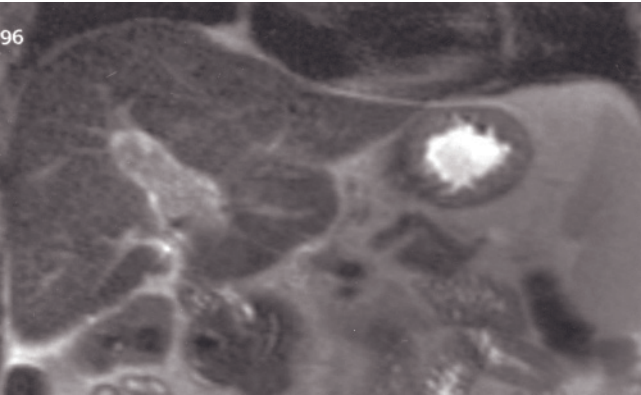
(Continued) Coronal (e) and transverse (f) T2-weighted SS-ETSE, SGE (g), and immediate (h) and 90-s fat-suppressed (i–j) postgadolinium SGE images in a second patient. There is a large irregular mass occupying the majority of segments 5 and 6 of the right hepatic lobe, with tumor thrombus (small arrows, e–j) extending into the right, left, and main portal veins. Interstitial-phase gadolinium-enhanced images clearly depict multiple lymph nodes (arrowheads, i–j).
